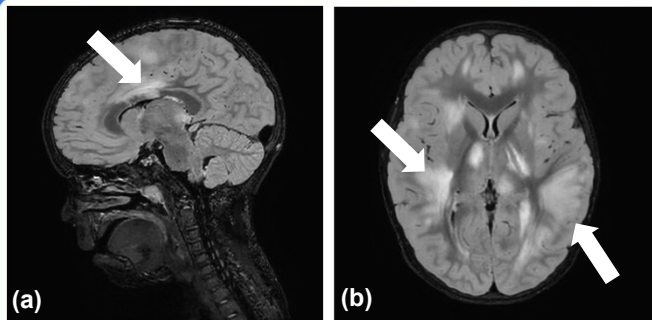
MRI on day 3 showing multiple T2 hyperintense white matter lesions (white arrows): (a) sagittal view, involvement of the corpus callosum, (b) axial view with "fluffy" hemispheric lesions involving the grey matter and cortical thickening, and (c) coronal view demonstrating bilateral thalamic involvement.
